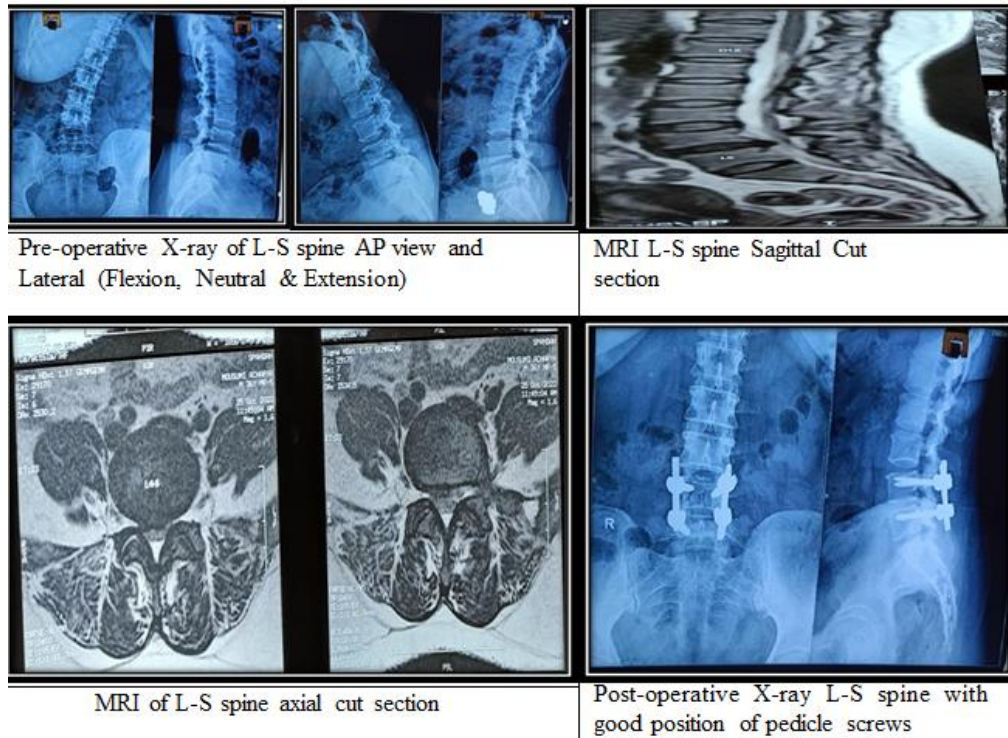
The radiological assessment during the preoperative and postoperative period of the Lumbo-Sacral Spine by the use of X-ray and MRI Imaging
